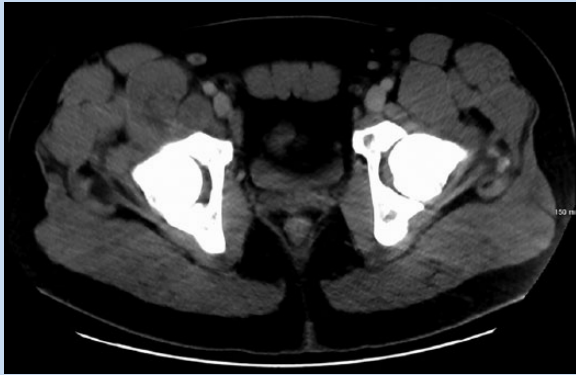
Computed tomography scan of an enlarged psoas muscle with soft tissue stranding.
